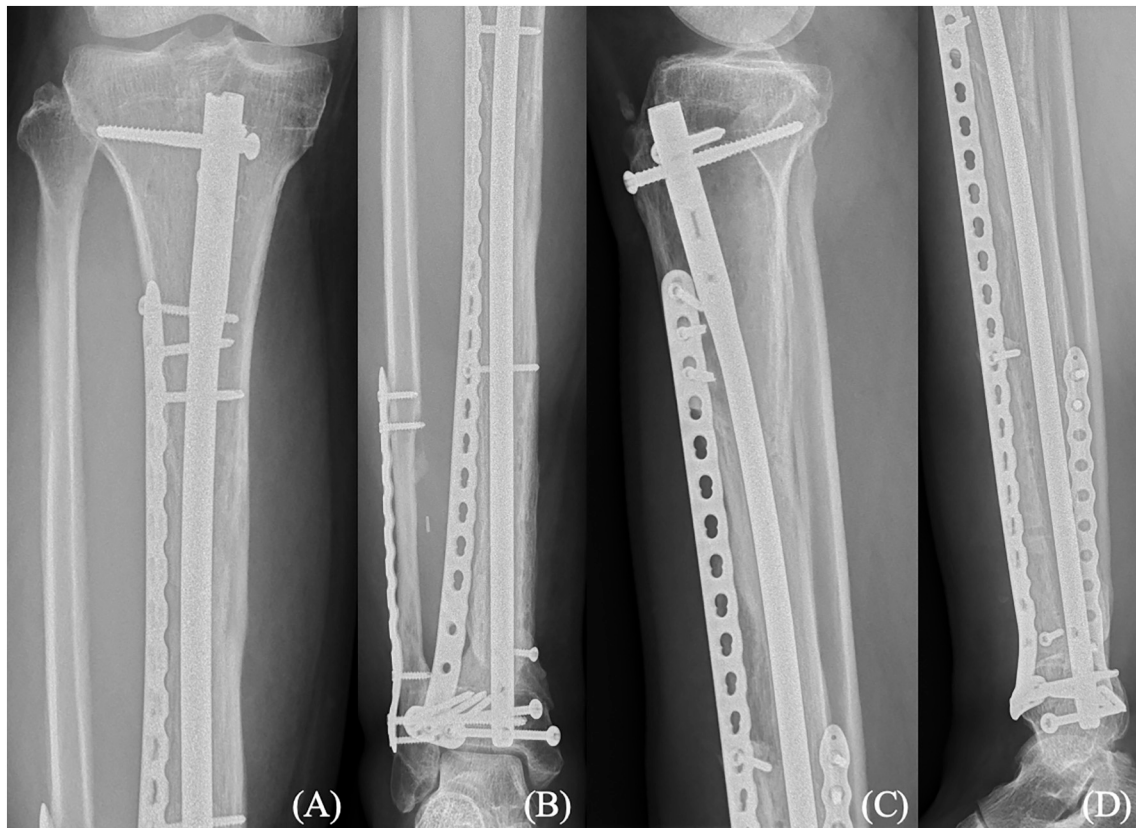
AP (A) & lateral (B) radiographs at 10 months follow-up showing docking of the transported bone segment and regenerate formation.
